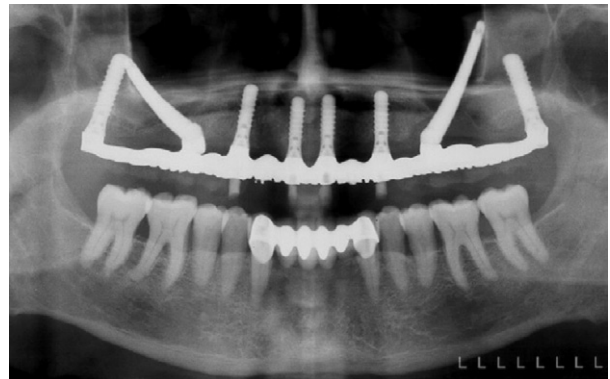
Case 6. Panoramic x-ray view after placement of the definitive screwed prostheses.
